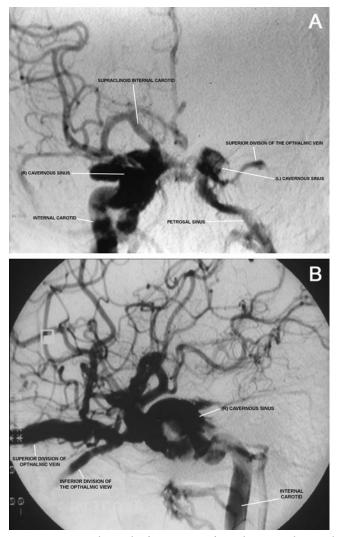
Radiographs from views of a right internal carotid angiogram. (A) Anterior–posterior (AP) view shows a typical high-flow fistula from the right carotid artery to the cavernous sinus. (B) Lateral view: typically type A fistulas are treated endovascularly from the arterial side.
